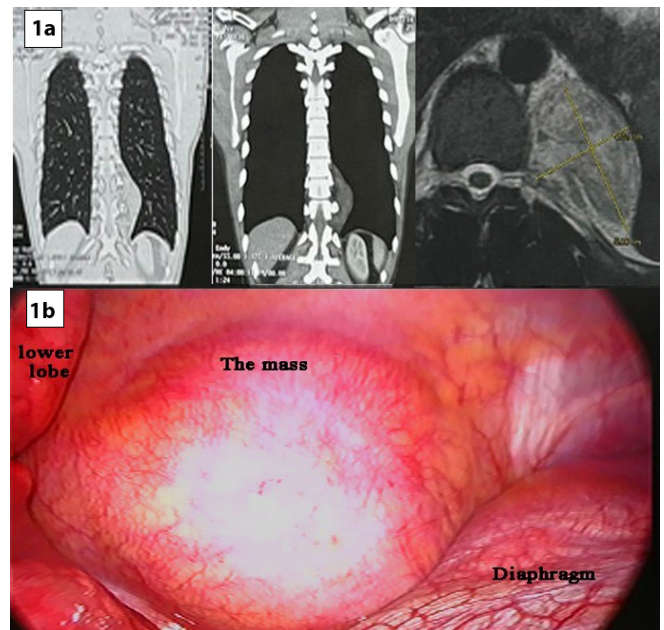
1a: CT and MRI demonstrating a left lower posterior mediastinal mass and its proximity to the spine; 1b: VATS localizes the precise relation of a mass to the surrounding
